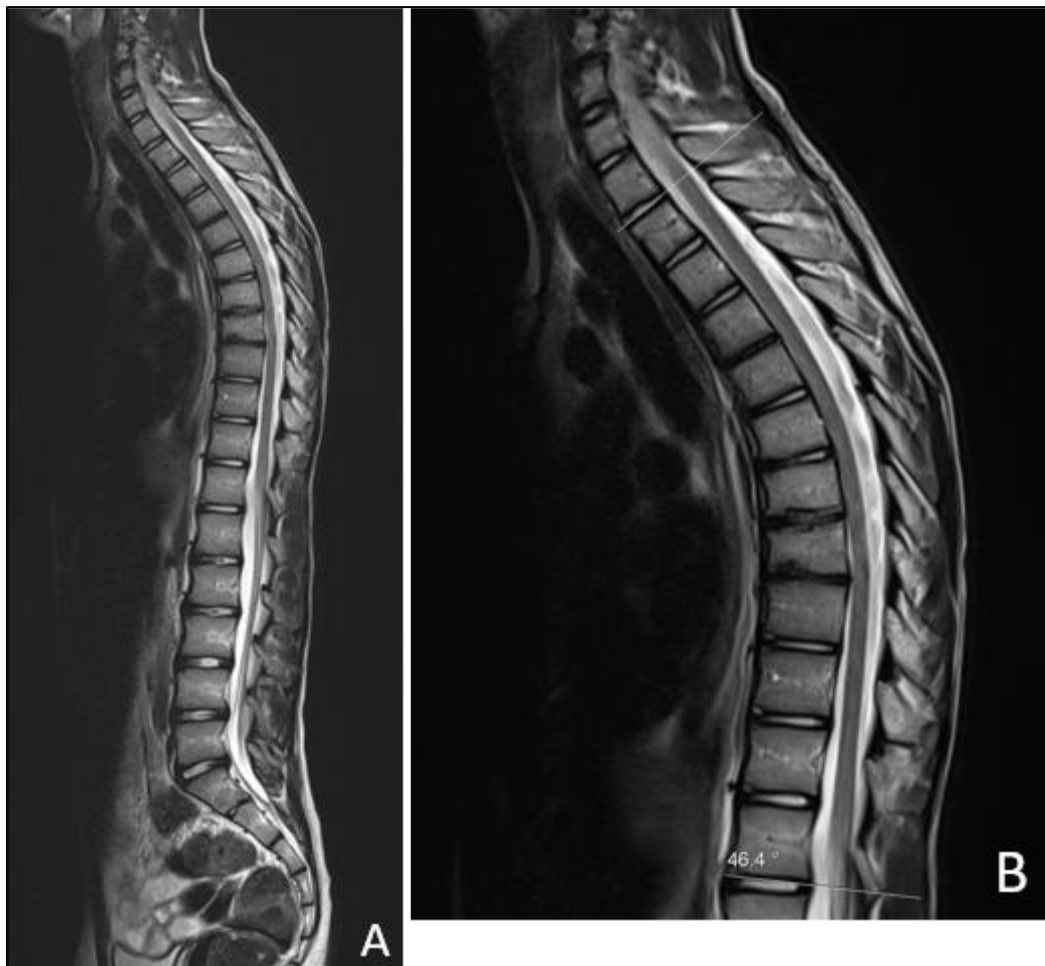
Sagittal T2-weighted images of the thoracic and lumbar spine. (A) Exaggerated thoracic kyphosis. (B) The Cobb angle is measured at 46 degrees; intersecting vectors are drawn from the superior endplate of T1 to the inferior endplate of T12, representing the boundaries of the kyphotic curve.
